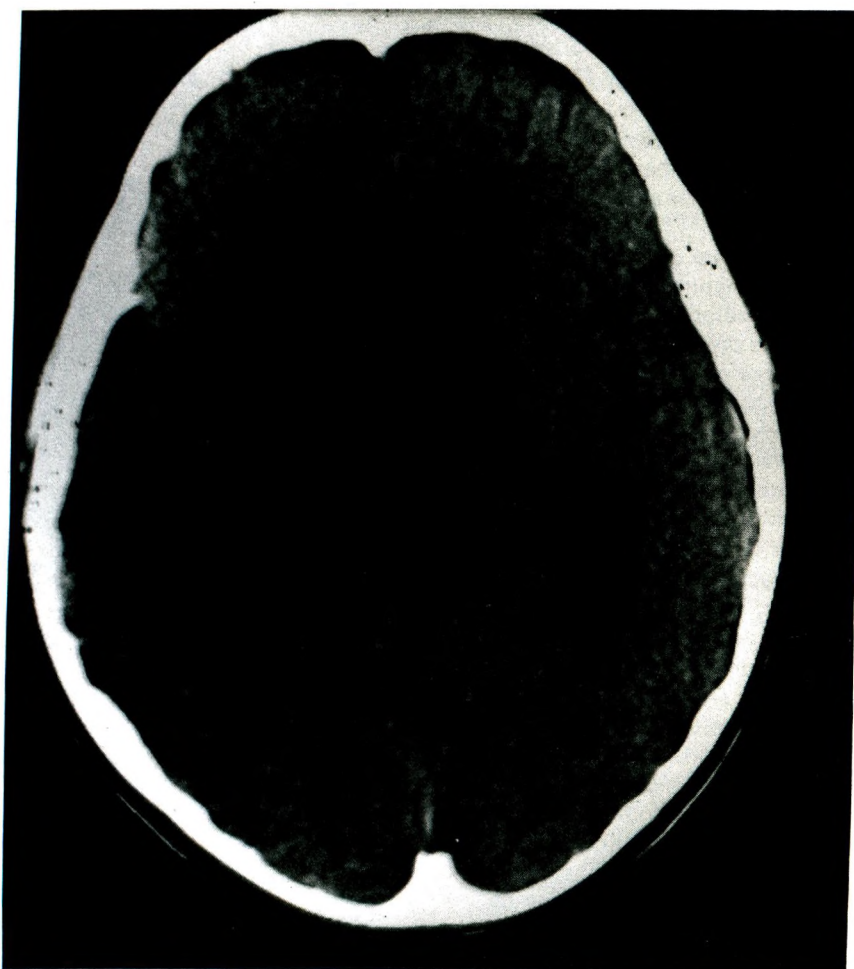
The third CT scan was normal.
